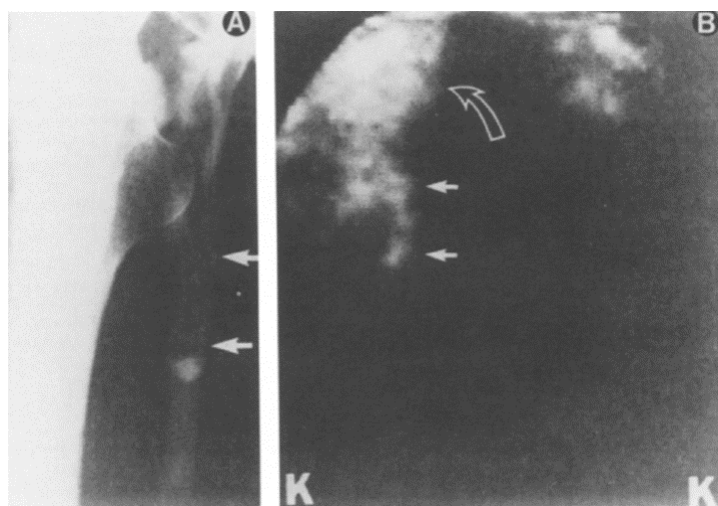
Thrombus imaging in a patient 5 days post total hip replacement. (A) Radiograph of the right hip using contrast venography, showing intraluminal filling defects (arrows), representing thrombosis. (B) ¹²³I-fragment E₁ scintigraphy performed within 30 min post injection showing diffuse radiotracer uptake around the implanted hip prosthesis (curved arrow) and focal tracer localization corresponding to the thrombus (straight arrow). K indicates the level of the knees. Reprinted from Knight et al. with permission from the publisher.⁶⁷*
